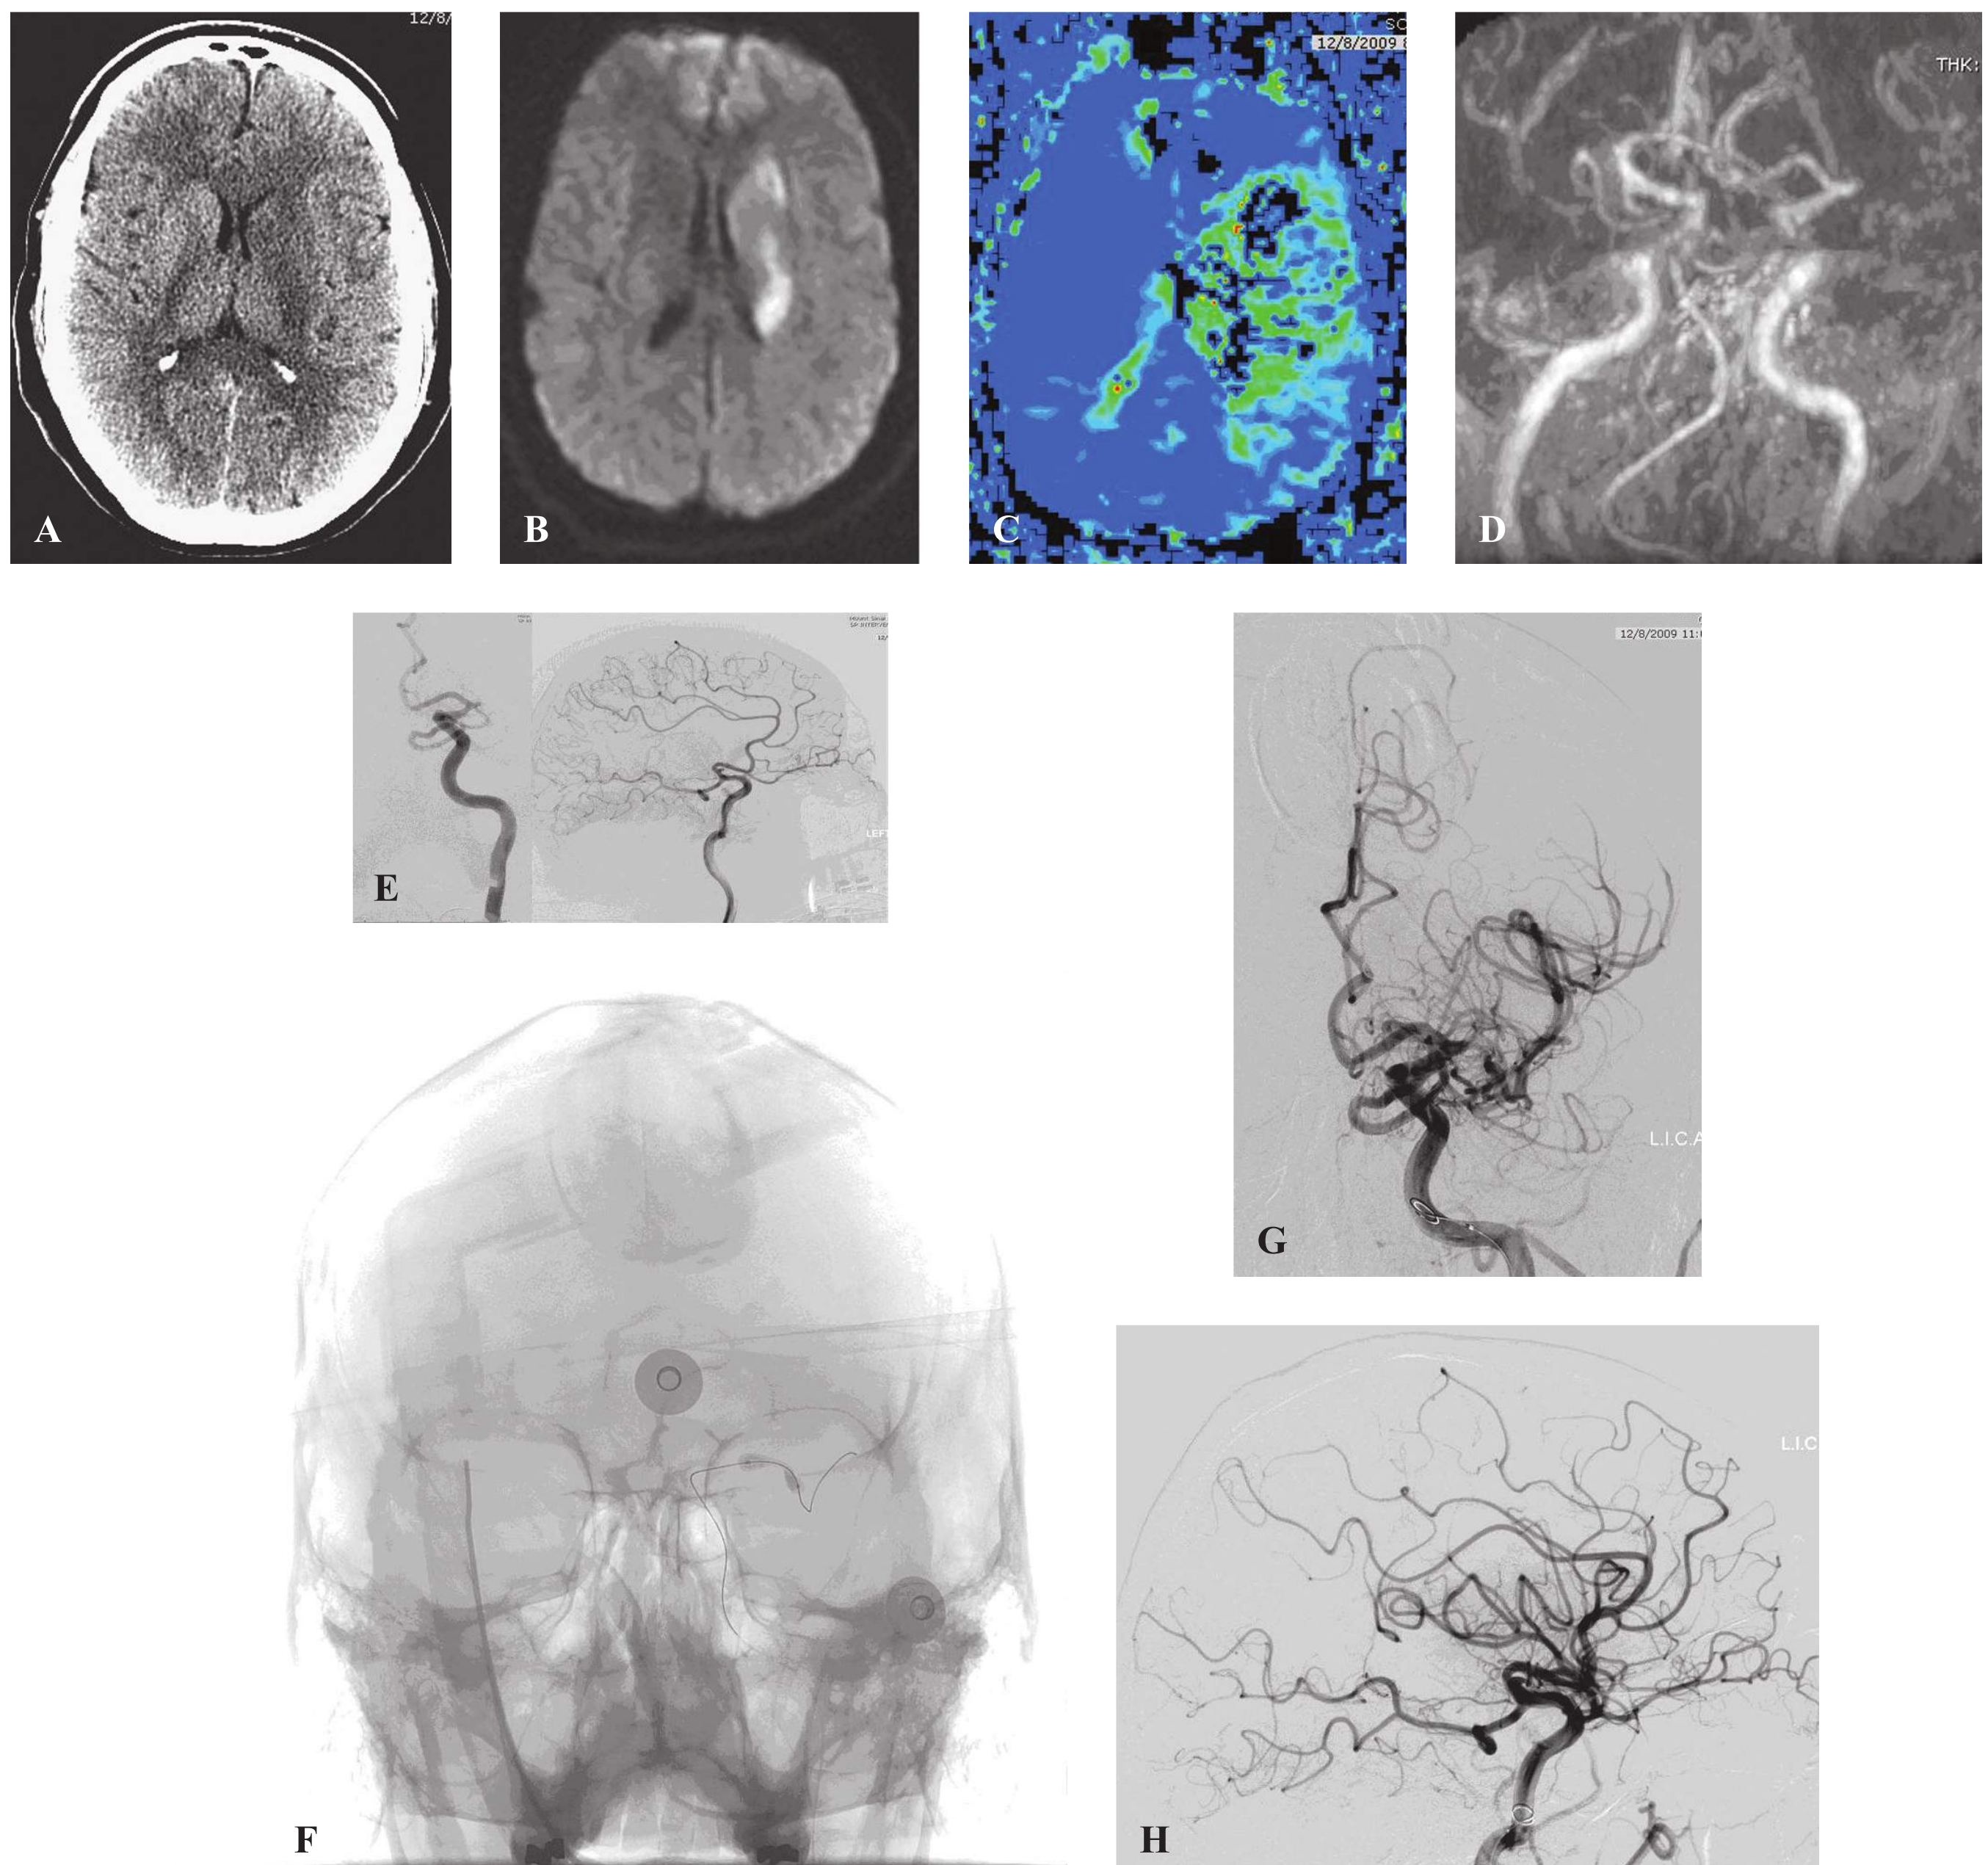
(A–H) A 45-year-old man presents with sudden onset of global aphasia and 2/5 hemiparesis at 3.5 hours onset time. The patient was not given IV rt-PA, although now, in light of ECASS III, he would have been a candidate. CT demonstrates no hemorrhage. Early findings in the caudate are more obvious on MRI/DWI. MRI perfusion demonstrates a full MCA territory perfusion defect. This case demonstrates well the concept of diffusion–perfusion mismatch. Clearly, there is brain to save (penumbra). The MRA demonstrates an occlusion of the left MCA M1 segment. Angiography confirms the left M1 occlusion. Intra-arterial rt-PA and the MERCI device were used unsuccessfully in efforts to recanalize the vessel. Angioplasty was performed successfully, leaving a mild residual stenosis. This correlates to the pathophysiology because the patient was using cocaine the previous night. Recall that cocaine induces transient platelet aggregability, vasospasm, and cardiac arrhythmias secondary to sympathomimetic effects. The patient’s residual deficit correlates to the original MRI/DWI: deficits that localize to the caudate. This is a clear demonstration of perfusion defect correlating to reversible deficits—proof of concept of the penumbra saved.
